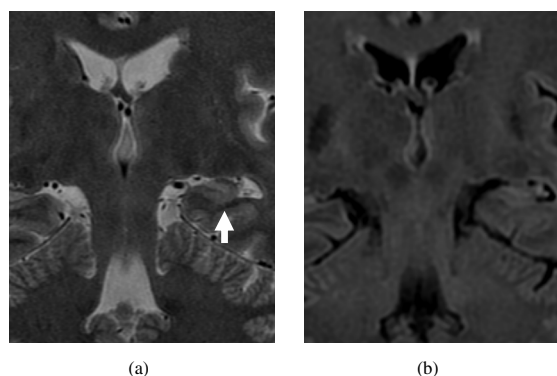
57-year old woman with left hippocampal sclerosis. T2WI (a) shows partial disappearance of LS (arrow), while FLAIR (b) is normal.
